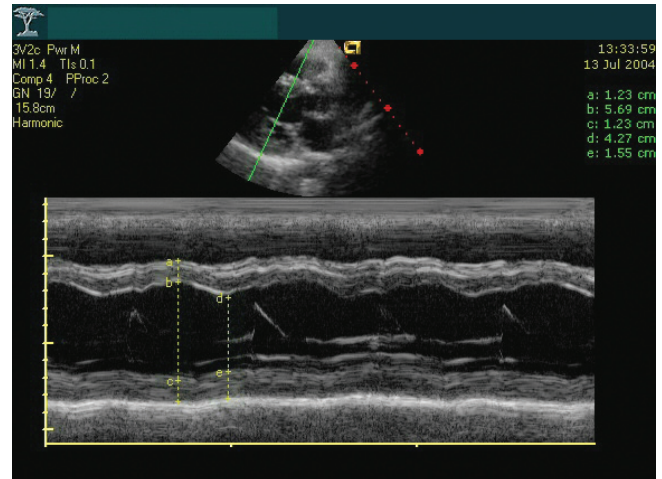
Parasternal left ventricular long axis M-mode demonstrating mild concentric hypertrophy and mild ventricular dilation with posterior hypokinesia
